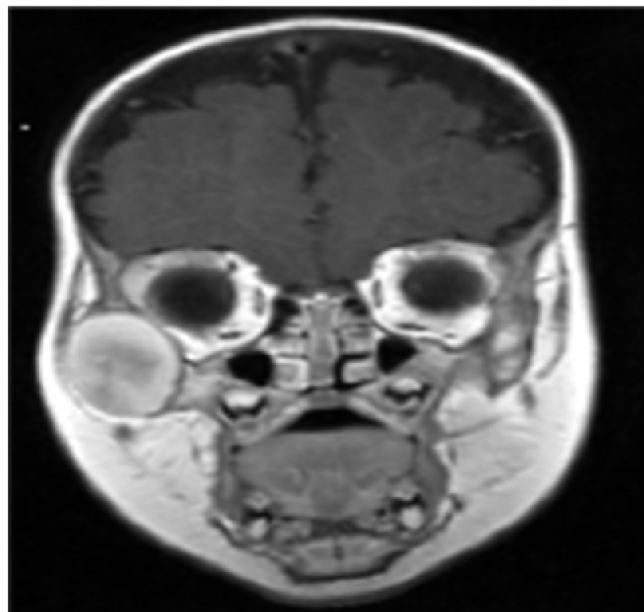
MRI at 10 months of age showing the tumor, $27 \times 28 \times 22$ mm in size.
